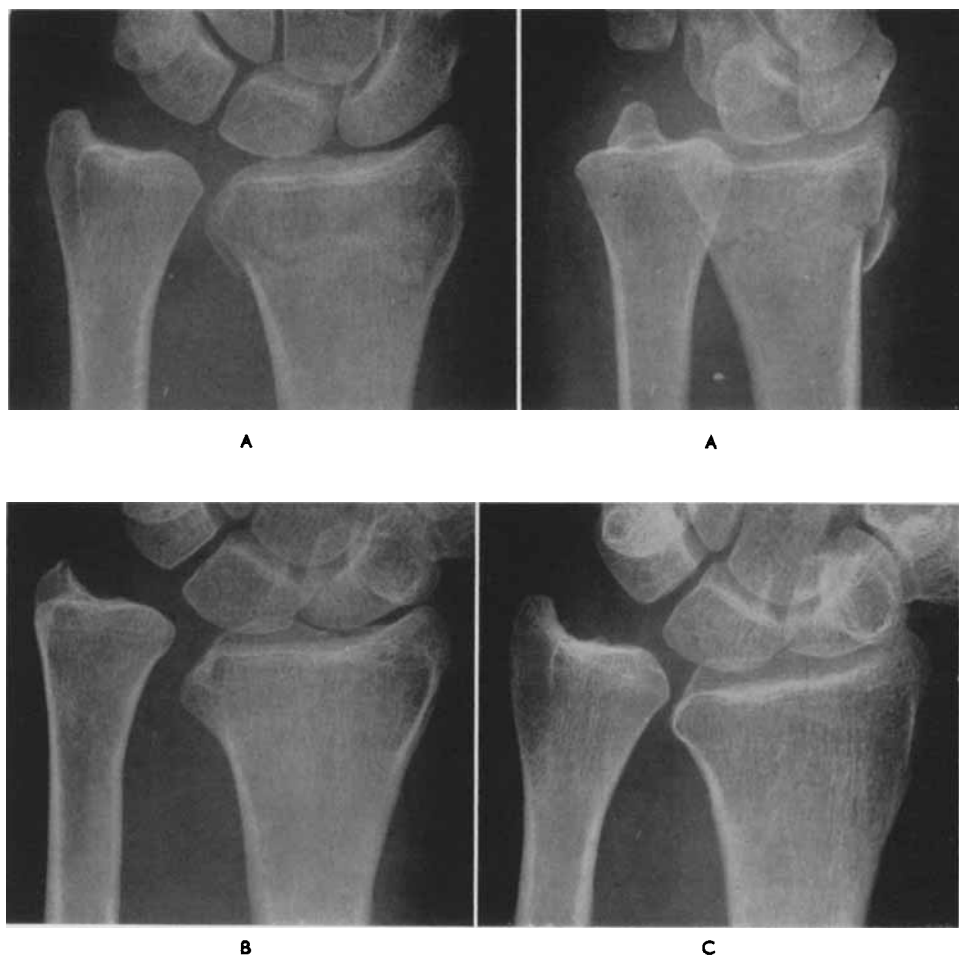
Woman aged 55. Fracture with slight primary displacement resulting in disability due to recurrent dislocation of the capitulum ulnae. *A.* Pre-reduction roentgenogram. *B.* Follow-up roentgenogram 4 years after injury. Clearly increased diastasis in the radio-ulnar joint in comparison with the uninjured wrist (*C*).
